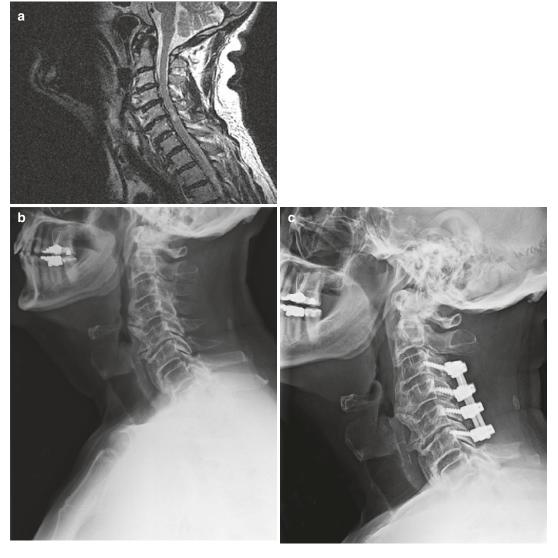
Diffuse idiopathic skeletal hyperostosis. (a) Sagittal T2-weighted magnetic resonance image demonstrating multiple levels of stenosis throughout the cervical spine in a patient with overt myelopathy on clinical examination. (b) Preoperative lateral radiograph demonstrating bridging osteophytes throughout the entire cervical spine. Although a multiple-level anterior cervical discectomy and fusion might be feasible in this patient, it
